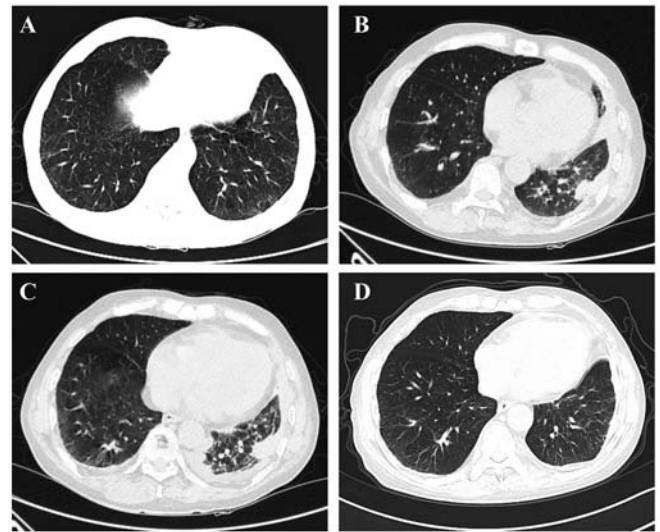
Nocardia* infection and chest CT scan results before and after treatment. (A) In September 2020, when the patient was initially diagnosed with anti-neutrophil cytoplasmic antibody-related vasculitis, the chest CT scan showed interstitial inflammation in both inferior lungs. (B) In April 2021, the patient developed pain in the left hip, and a plain chest CT scan on the first day of admission indicated a new left encapsulated pleural effusion. (C) At 12 days after admission, during the hospitalization for the diagnosis and treatment of *Nocardia* infection, a repeat plain chest CT scan indicated a small amount of bilateral pleural effusion, and the left region was encapsulated slightly more than before. (D) In May 2021, 11 days after the patient was discharged, a repeat plain chest CT scan indicated that the left encapsulated pleural effusion had completely disappeared.
